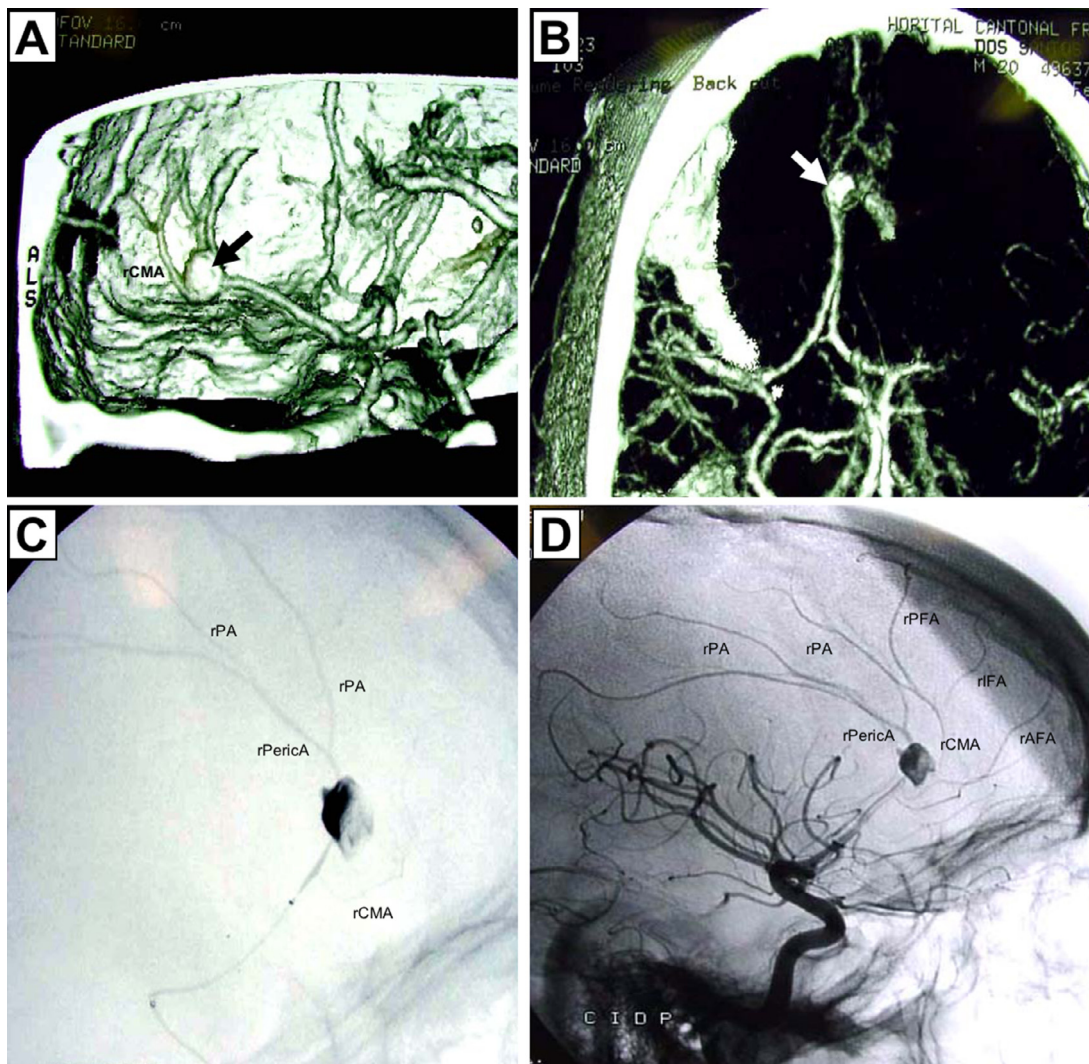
Case 1: Sagittal (A) and axial section (B) of three-dimensional CT-Angio display an aneurysm (arrow) of the distal right anterior cerebral artery (dACA), distal to the origin of the right callosomarginal artery (CMA). Digital subtraction angiography (right internal carotid, lateral view) reveals a 14 × 10 mm partially thrombosed aneurysm of the right pericallosal artery (rPericA) (C, D). AFA = anteromedial frontal artery; CMA = callosomarginal artery; CT = computed tomography; IFA = interomedial frontal artery; l=left; PA = paracentral artery; PericA, pericallosal artery; PFA = posteriomedial frontal artery; r = right.
